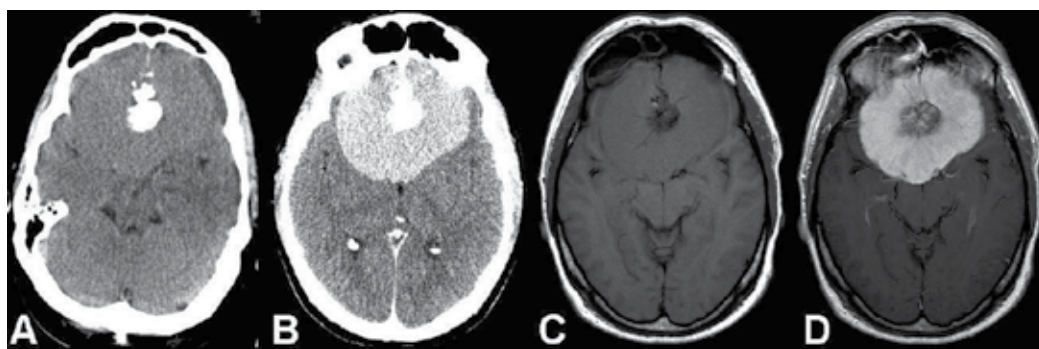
Computed tomography (A: native and B: with contrast) and magnetic resonance imaging, T1 weighted (C before and D after gadolinium) revealing a huge tuberculum sellae meningioma with central calcification and homogenous contrast enhancement (B, D).
